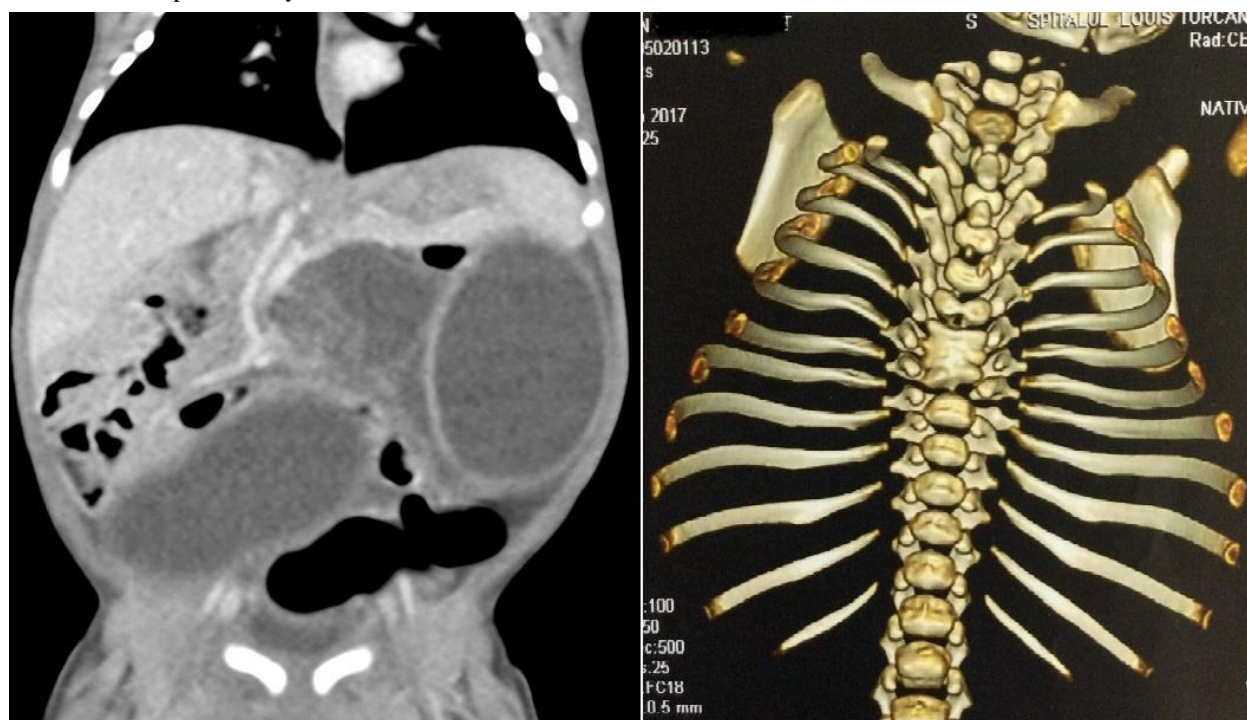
Computed Tomography Image of the Duplication and 3D Reconstruction to better highlight the vertebral malformation.
